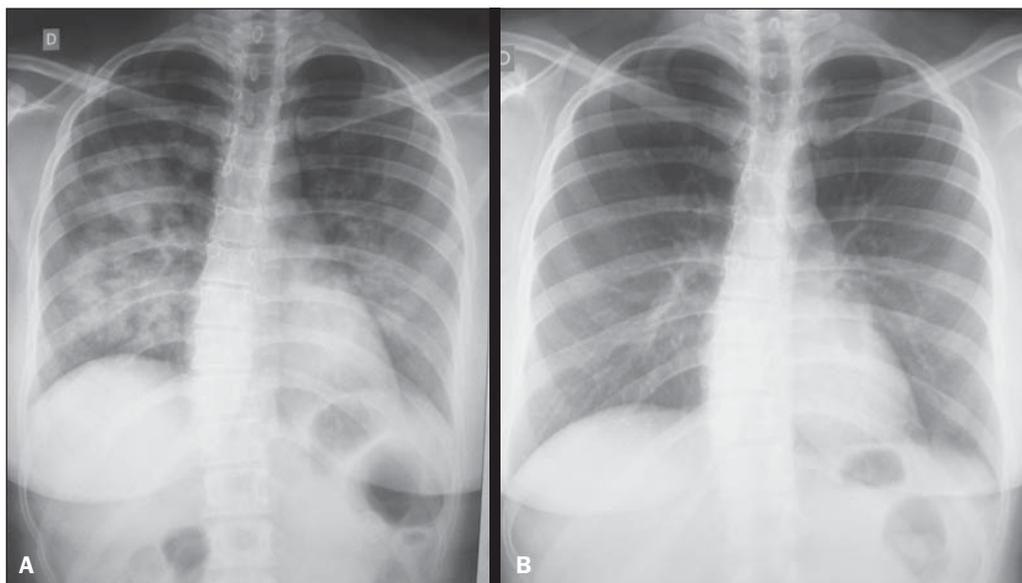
A: Posteroanterior chest radiographic image showing bilateral, coalescent, poorly defined opacities, characterizing the so called “butterfly wing” pattern, which is typical of alveolar process. The cardiac image is normal. These images were acquired on the following day after tonsillectomy. The patient presented with mild dyspnea. B: Posteroanterior chest radiographic image acquired three days after the procedure. Complete resolution of the alveolar process demonstrated on the previous images.
